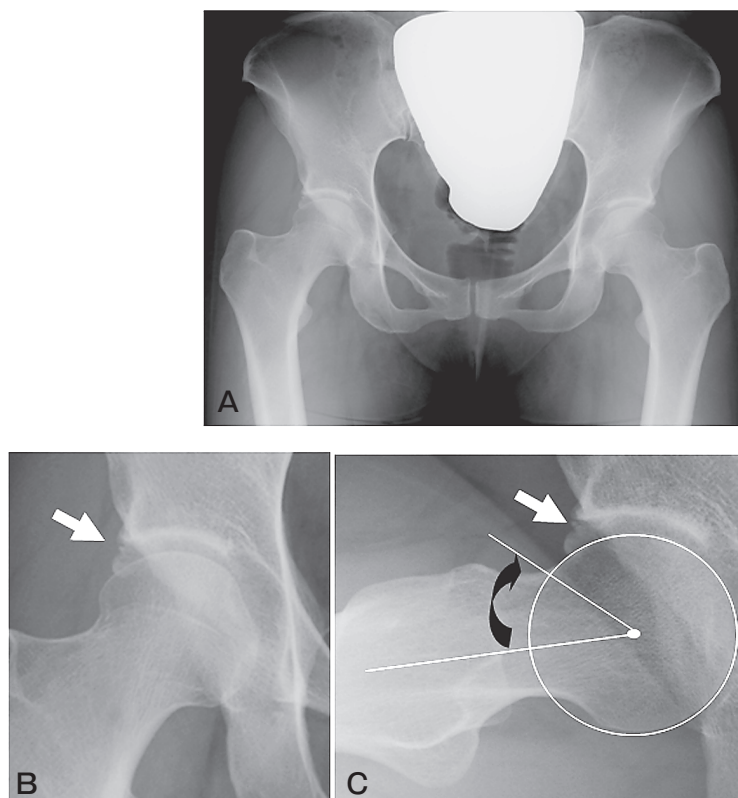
The initial radiograph. A, A-P view; B, Osseous protrusion (arrow) in right hip joint seen by the expansion of A-P view; C, Osseous protrusion (white arrow) in anterior-superior site seen by expansion of the lateral view. The α angle (black arrow) was 40 degrees and head-neck offset was 12 mm.
